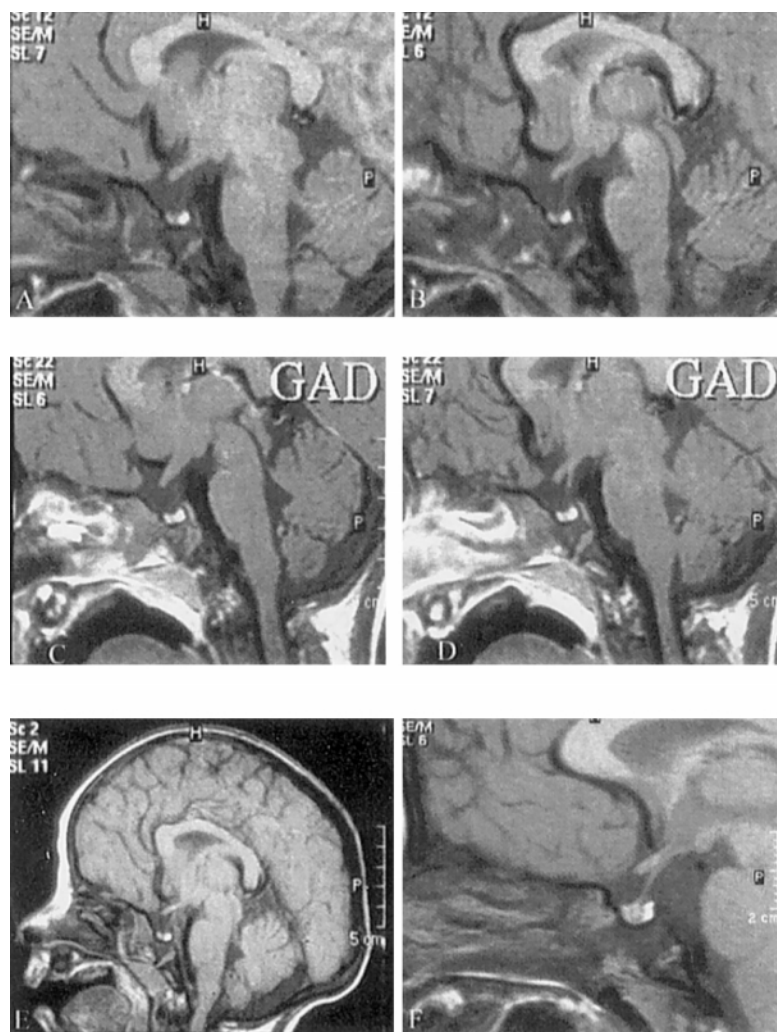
MRI of the brain including the hypothalamic-pituitary area with and without GAD revealed hypoplasia of the anterior pituitary with loss of volume (between 120 to 290 μ L) (A and B), borderline pituitary volume (450 to 550 μ L) (C, D, and E) and normal volume (550 to 1050 μ L) (F).
